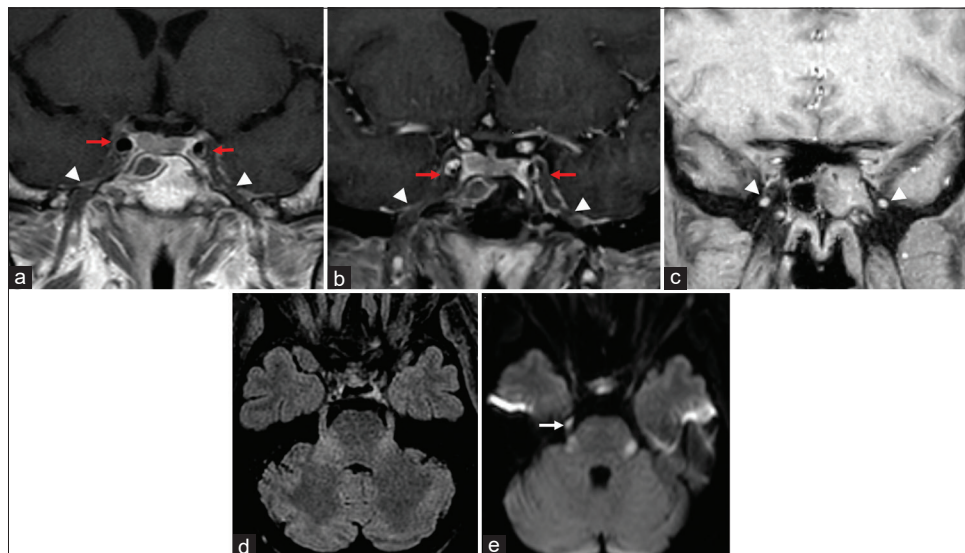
Brain magnetic resonance imaging examination at neurological onset. Coronal contrast-enhanced fat saturation T1-weighted (a and b), coronal basal fat saturation T1-weighted (c), axial fluid-attenuated inversion recovery (d), axial diffusion-weighted (e) images. (a and b): Bilateral cavernous sinus thrombosis (arrows), bilateral V3 swelling without contrast enhancement (arrowheads); (c): bilateral V2 swelling (arrowheads); (d and e): high signal bilateral pontine foci, due to perineural diffusion. Note diffusion restriction at intracisternal tract of right trigeminal nerve (white arrow).
